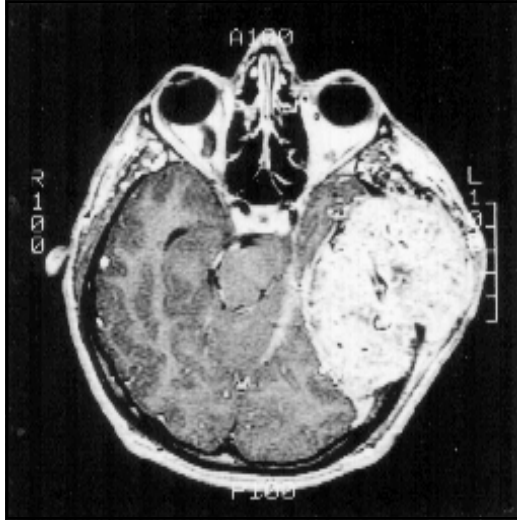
T1-weighted magnetic resonance image. Axial view with gadolinium enhancement showing a well-circumscribed lesion causing mass effect against temporal parenchyma.
